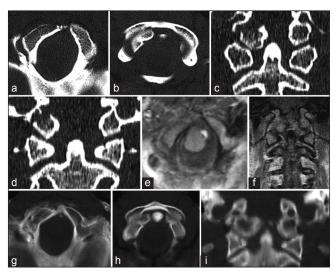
Fracture of the right occipital condyle; Anderson & Montesano III; Tuli 2A. a-d): Computed tomography after trauma: Condylus occipitalis fracture on the right side with typical mediocaudal dislocation of the fragment. e-f): The MRI shows neither a spinal hemorrhage nor an oedema of the spinal cord. The dislocated fragment is also clearly visible. g-i): Computed tomography 30 months after the accident: The fragment of the occipital condyle is consolidated in the dislocated position.
